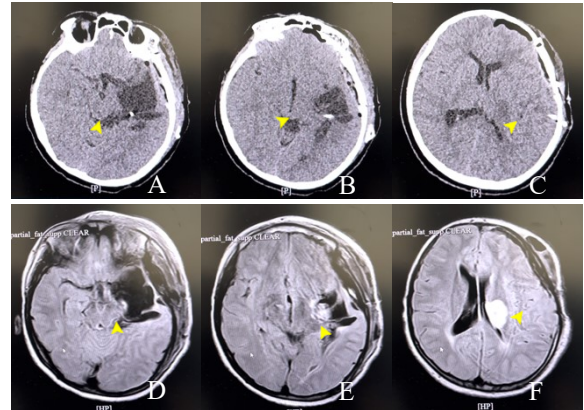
CT Scan head without IV contrast (A-C) and MRI head without IV contrast (D-F) showed that a ventriculoperitoneal shunt was placed through the left temporal region, with the tip located in the subarachnoid space of the left temporal region (yellow arrowhead)
